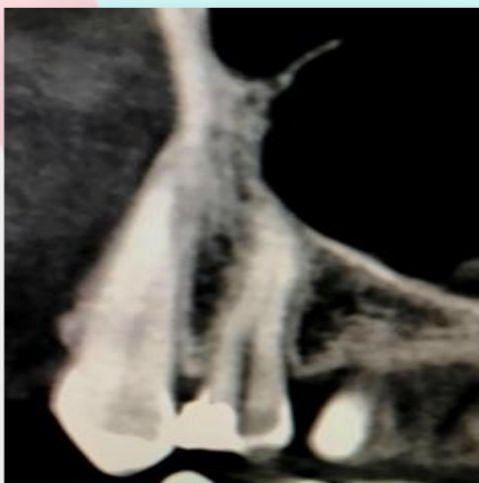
CBCT of tooth 24 after four years of biological treatment. The dental pulp, periodontium, and maxillary sinus integrity are preserved.
